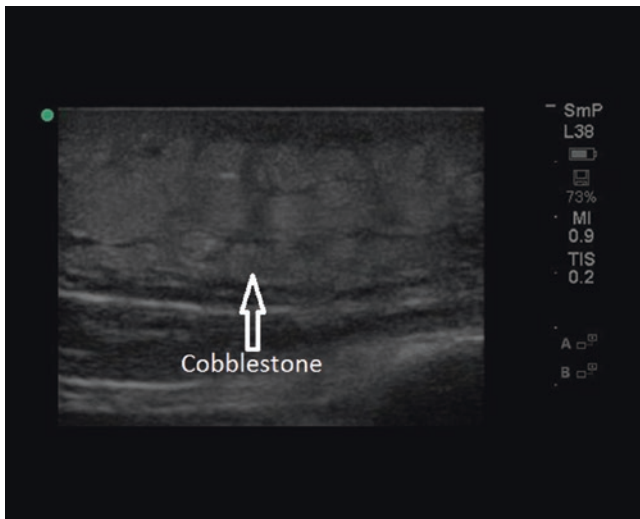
Cellulitis can be differentiated from abscess by soft tissue ultrasound. Interstitial edema surrounding subcutaneous adipose is a hallmark of this disease and it is referred to as “cobblestoning.” Although cobblestone appearance is common in cellulitis, it is advanced finding. Early cellulitis may appear as generalized swelling with increased echogenicity of the skin and subcutaneous tissues. Image courtesy of Ee Tay
